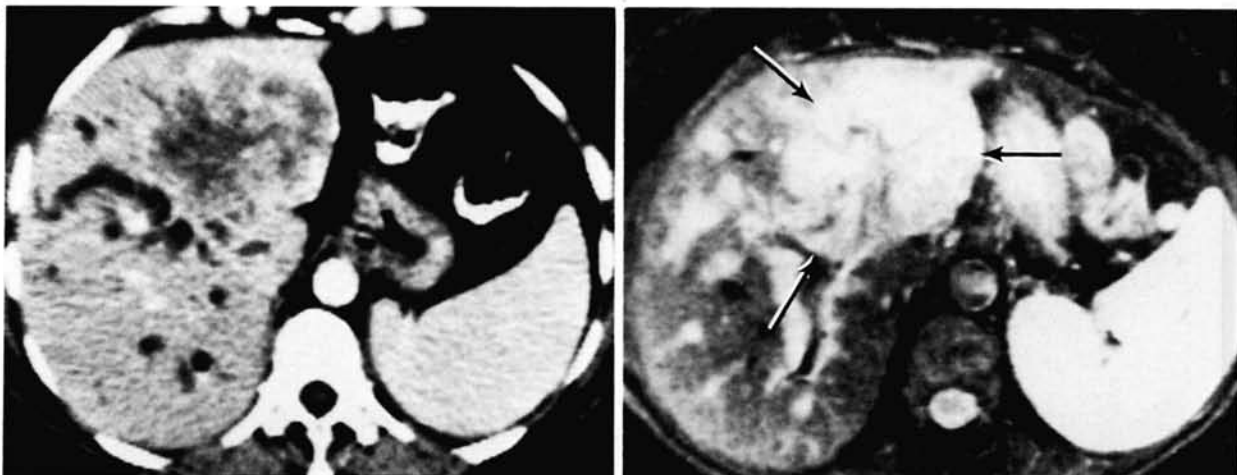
Cholangiocarcinoma: contrast enhanced CT (a) and inversion recovery (IR)_{1,500/100/44} (b) scans. The extent of the tumour is well seen in (b) (arrows).
